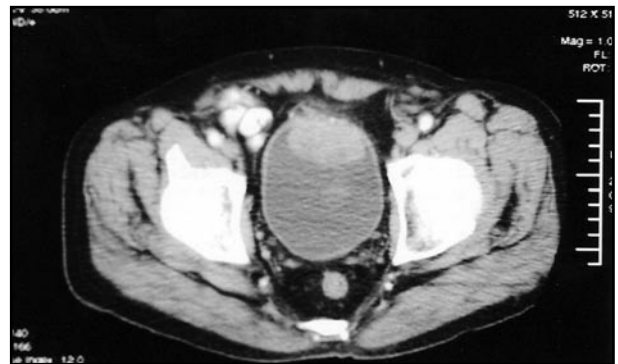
Preoperative CT scan showing huge urinary bladder tumor located at the dome
